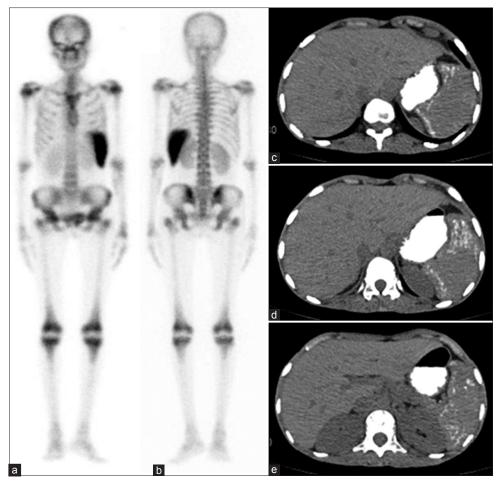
Diffuse increased radiotracer uptake in the left upper quadrant of the abdomen just superolateral to the left kidney, suggesting uptake in the spleen (a: anterior and b: posterior images). Heterogeneous calcification in the splenic parenchyma on computed tomography abdomen (tranaxial images, c-e)
